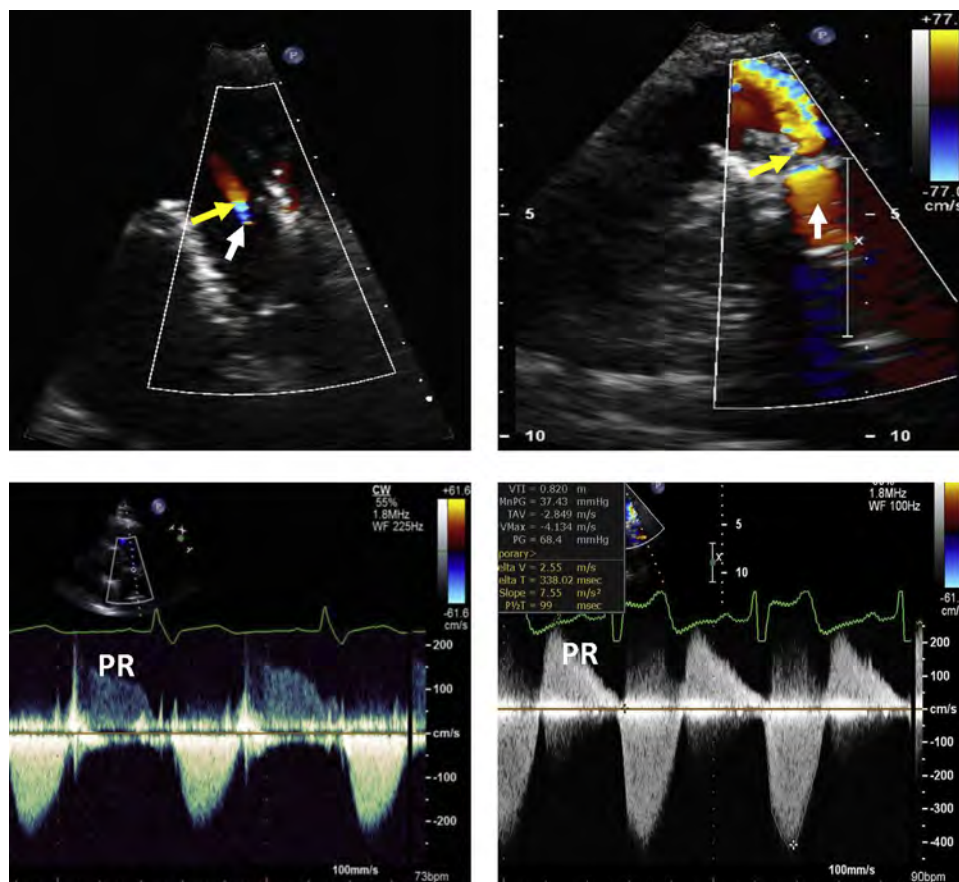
Examples of patients with mild (left panels) and severe (right panels) pulmonary regurgitation (PR) after TPVR are shown. The width of the color jet is depicted by the *yellow arrows*. Note also the difference in flow convergence (*white arrows*). Lower panels show examples of CWD recordings of mild and severe PR. The density of the spectral Doppler waveform (faint versus dense, particularly in relation to systolic flow) and the slope of the decrease in velocity in diastole (long vs. short pressure half-time) are apparent.
